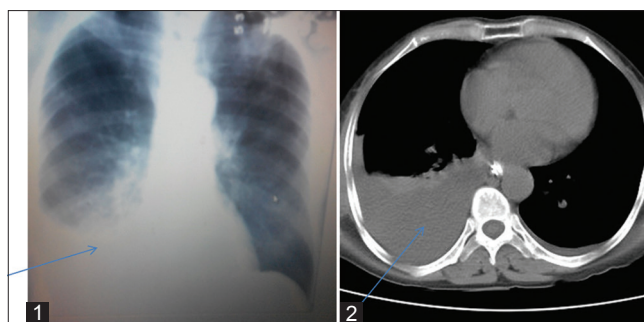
(1) Chest X-ray and (2) computed tomography (CT) showing right pleural effusion
